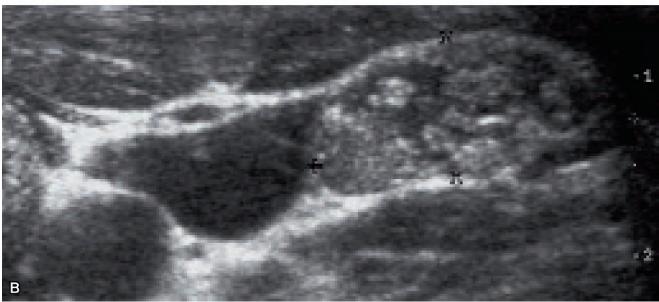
Ultrasound of lymph node metastases from papillary thyroid carcinoma: left segments 3 and 4. A, Longitudinal Transverse diameter: 13 mm. B, Transverse, 8 x 18 mm.
